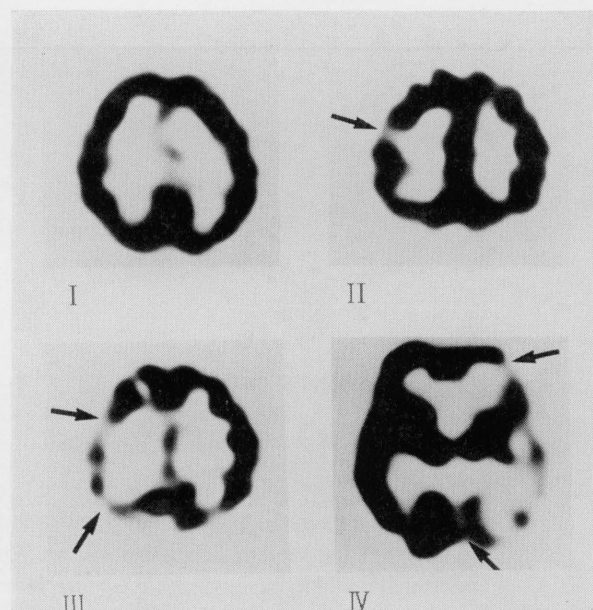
An example of each SPECT class. SPECT images showing no hypoperfusion (I), showing a hypoperfused area with a maximum diameter less than 2.0 cm. (II), showing hypoperfused area larger than 2.0 cm involving less than one lobe (III), and showing hypoperfusion with multilobe involvement (IV). Hypoperfused areas are indicated by arrows. The images are displayed with a grey scale from 15% to 100% of the maximum counts.
